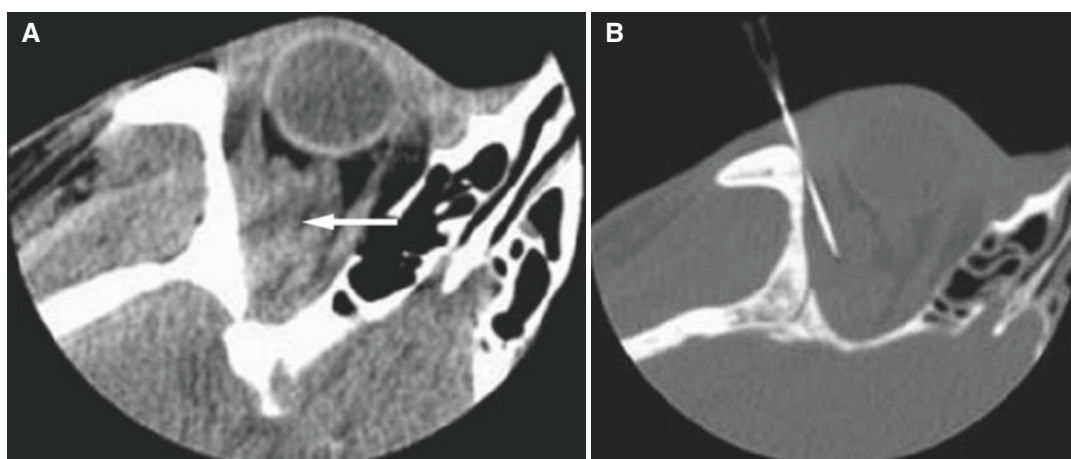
CT fluoroscopy-guided biopsy of orbital mass. (A) Axial CT image shows intraorbital mass (*arrow*) in posterior lateral aspect of right orbit. (B) Axial CT image, bone window, shows fine needle, 25 gauge, in correct position; aspiration revealed signs of hemangioma
